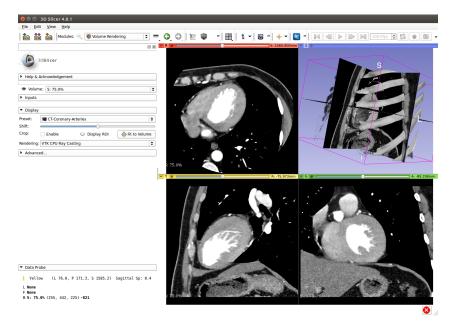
CT-Scan images in 3D Slicer GUI with Volume Rendering.
